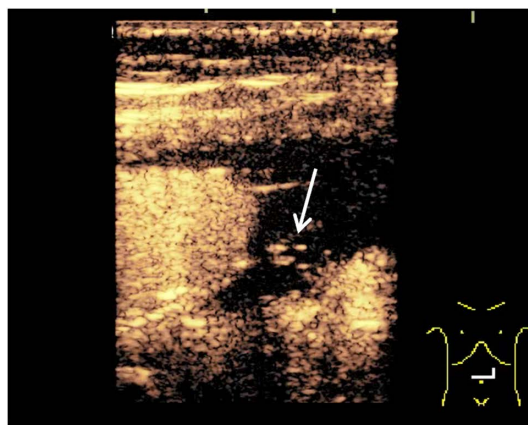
Contrast-enhanced ultrasound image of the slow endoleak case at 2 min after injection of the contrast material. A small amount of the contrast material is detected (white arrow) in the aneurysm sac.
